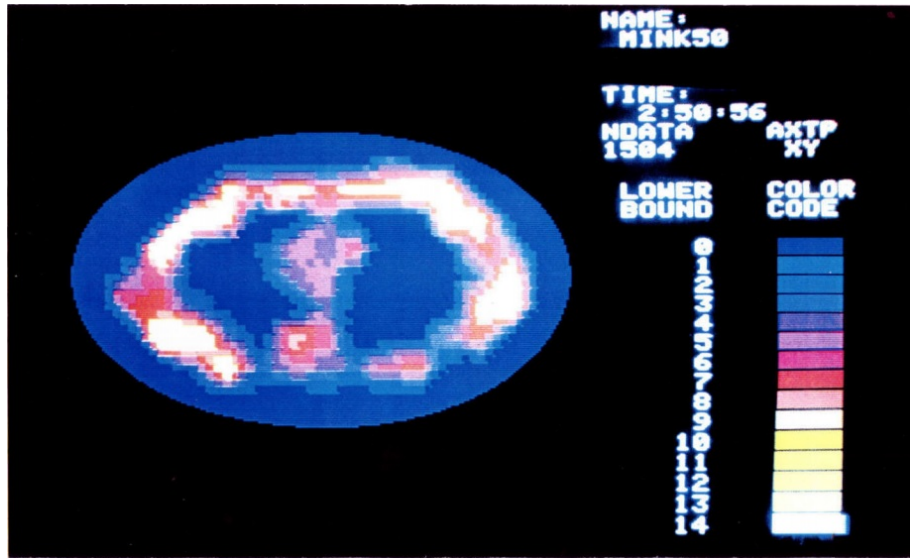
(Damadian et al. 1977) First MRI Image
